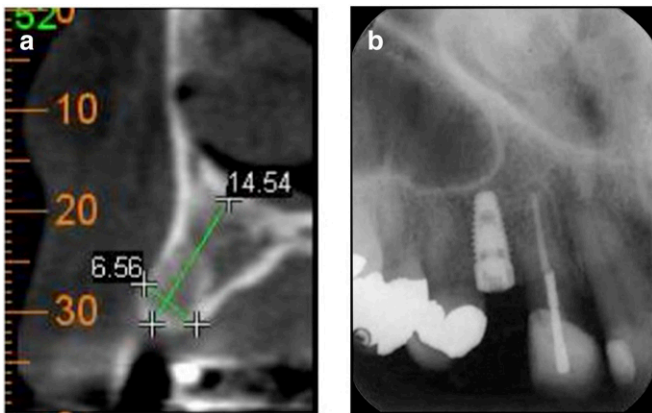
CBCT cross-section of proposed implant site. 8b Periapical radiograph after implant placement.
